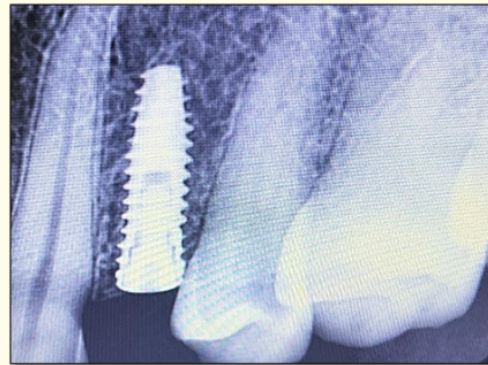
Postoperative periapical radiograph after implant placement.
